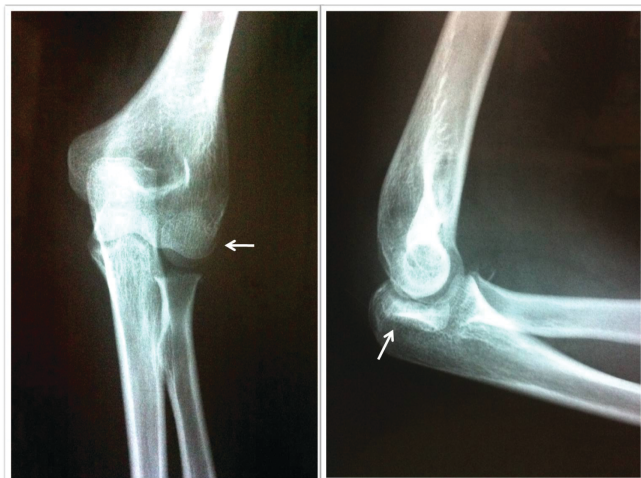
Anteroposterior and lateral radiographs demonstrating posterior elbow dislocation.
